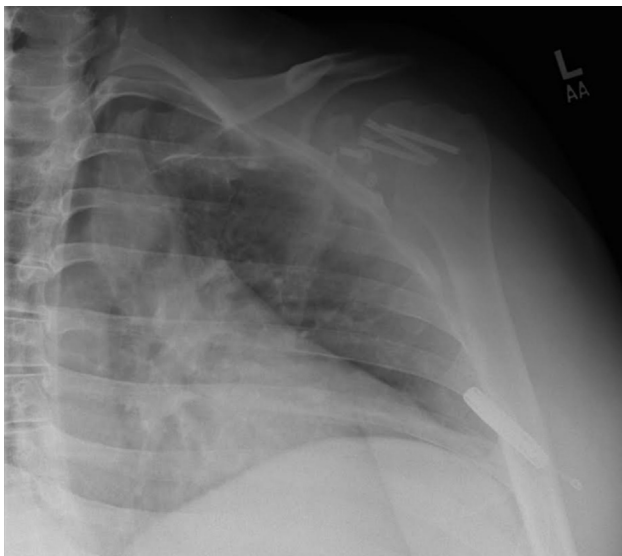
Postoperative scapular-Y x-ray film.
